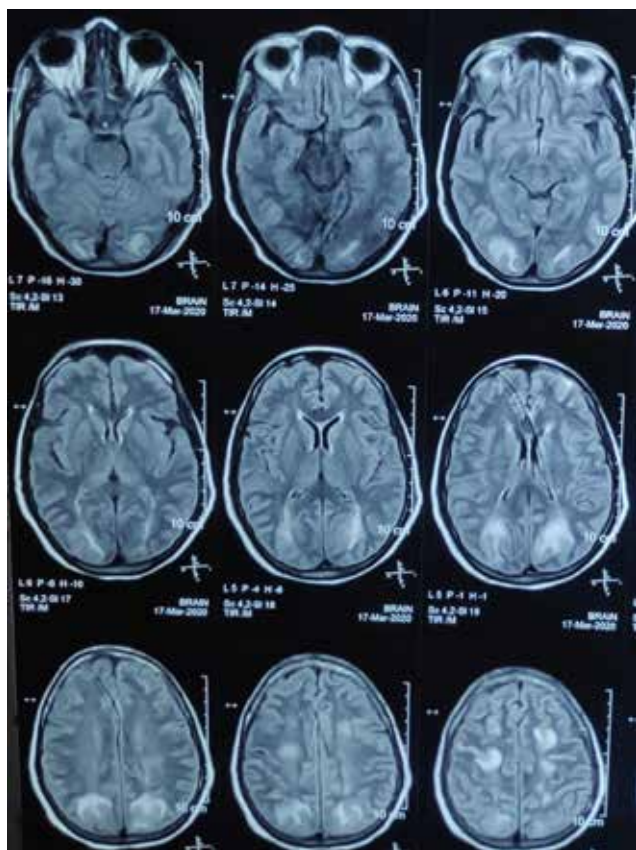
Axial Sections of T2/FLAIR Sequence of Brain MRI in PRES, Secondary to Eclampsia, Showing Hyperintensities, Predominantly in the Region of Posterior Circulation
